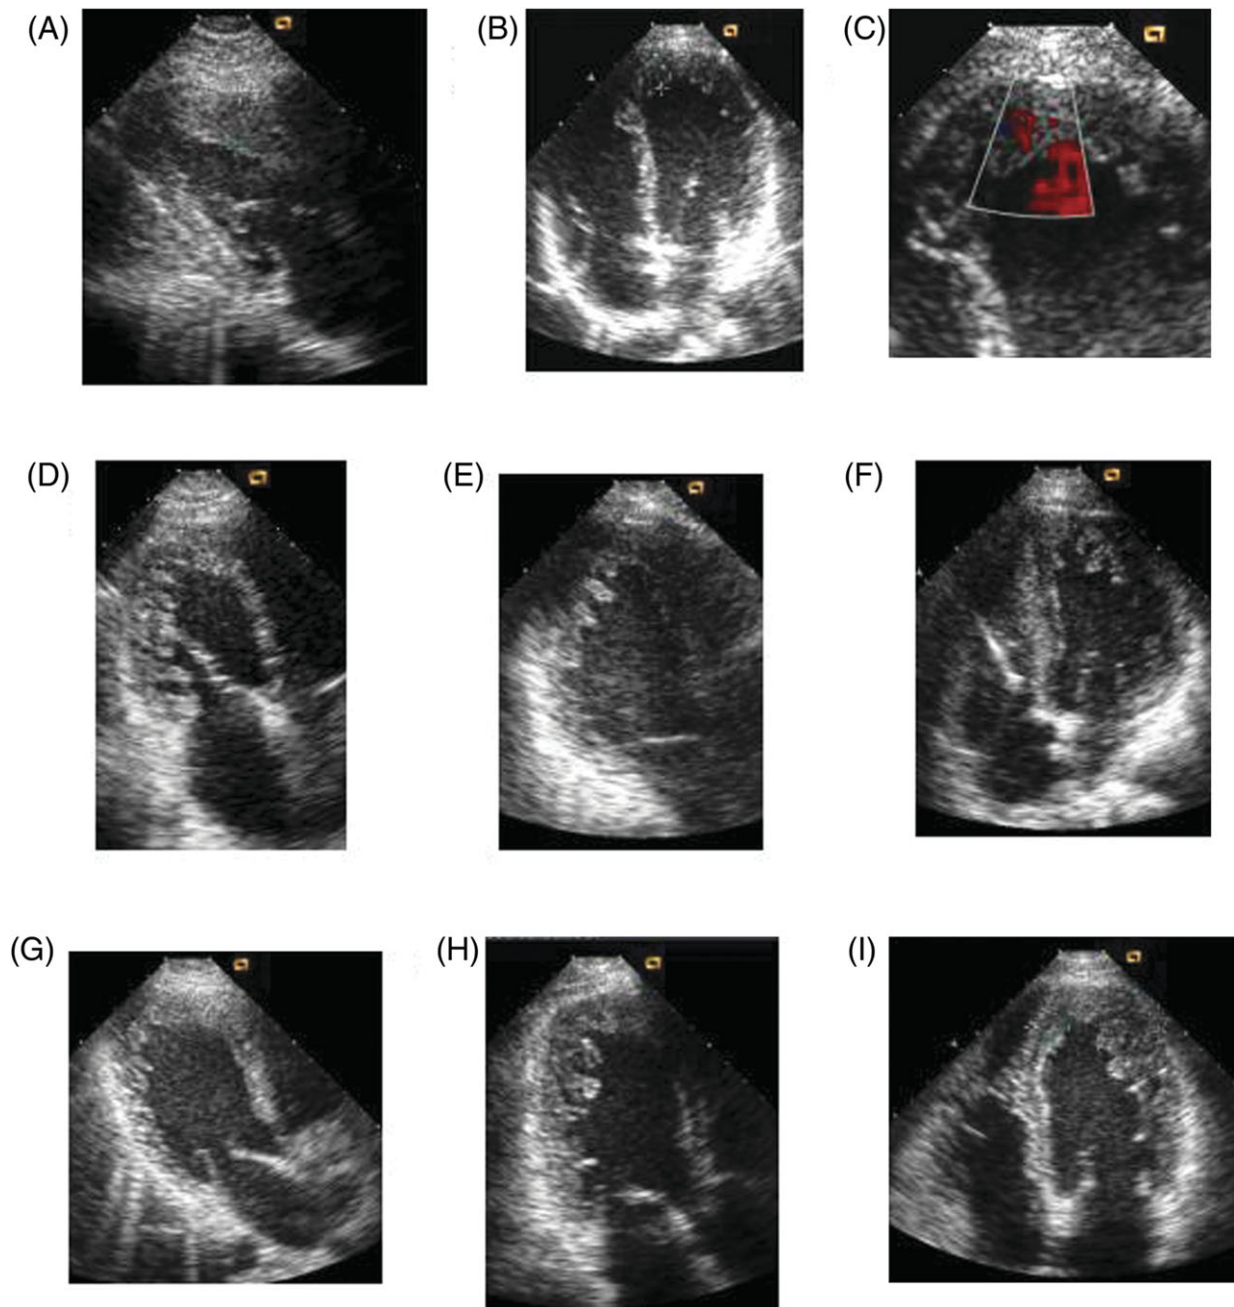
Patients from Families 2 (A–C), 3 (D–F), and 4 (G–I). (A) Two-chamber view patient II:2, Family 2, showing anterior wall hypertrophy without trabeculation. (B) Apical four-chamber view patient III:1, Family 2, with apical trabeculation. (C) Colour Doppler image of the apex of the same patient shows invaginations. (D) Modified apical three-chamber view patient II:3, Family 3 with non-compact posterior wall. (E, F) Apical three- and four-chamber views patient III:3 of Family 3 showing prominent lateral and posterior wall trabeculation. See defibrillator lead in the right ventricle. (G) Modified three-chamber view patient III:25 (Family 4), similar to *Figures 2D* from Family 1 and *3D* from Family 3. (H–I) Apical three- and four-chamber views of patient III:24 of Family 4, very similar to *Figure 3E* and *F* from Family 3.
